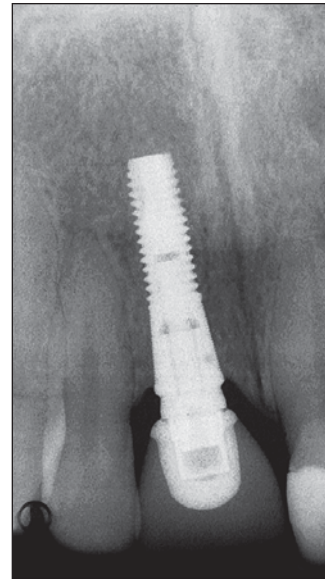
Radiographic evaluation of an implant-supported crown at 3 years following implant placement. Crestal bone adaptation appeared to follow the clinical crown-abutment contour, and bone contact at the implant approximated the implant-abutment interface.
